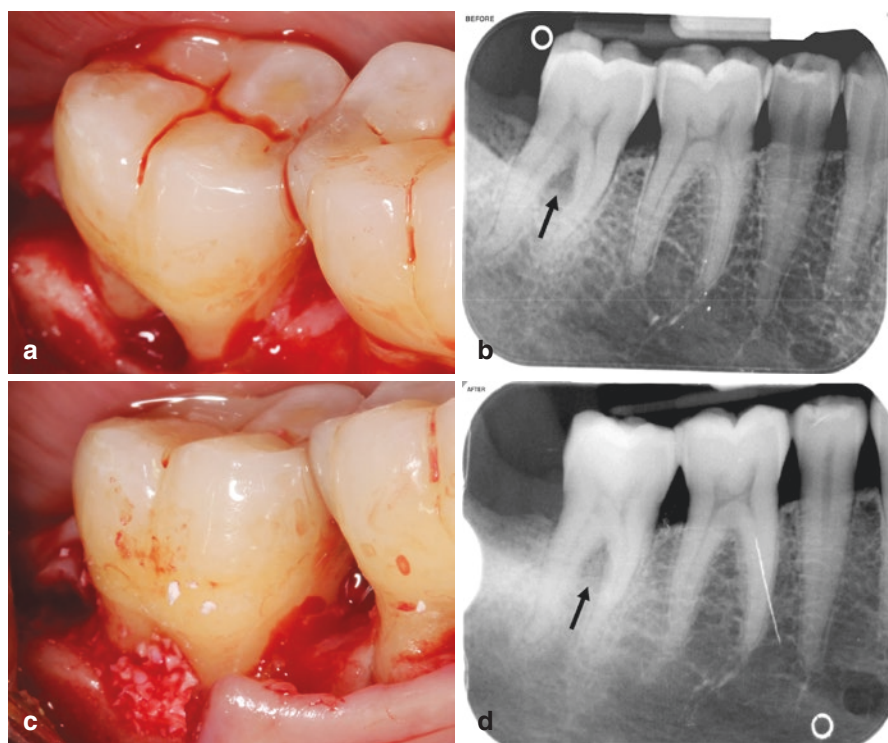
Regeneration procedure performed on a mandibular second molar with furcation involvement. (a) Preoperative radiograph and (b) flap reflection demonstrating class II furcation involvement. (c) Placement of EMD and xenograft. (d) Postoperative radiograph taken at 6 months demonstrating radiographic evidence of bone fill in furcation. Photos courtesy of Dr. Bruno Herrera
